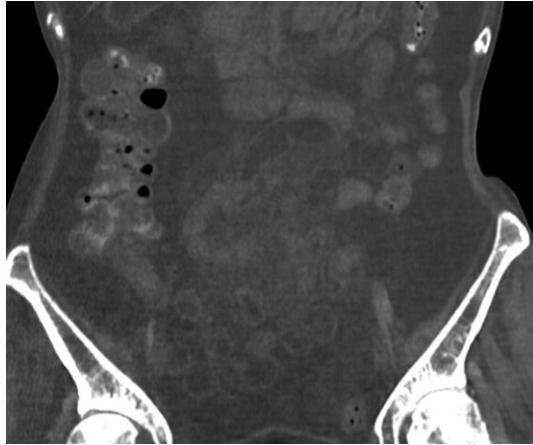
CT image after the resolution of the intussusception. There is no tumorous lesion
